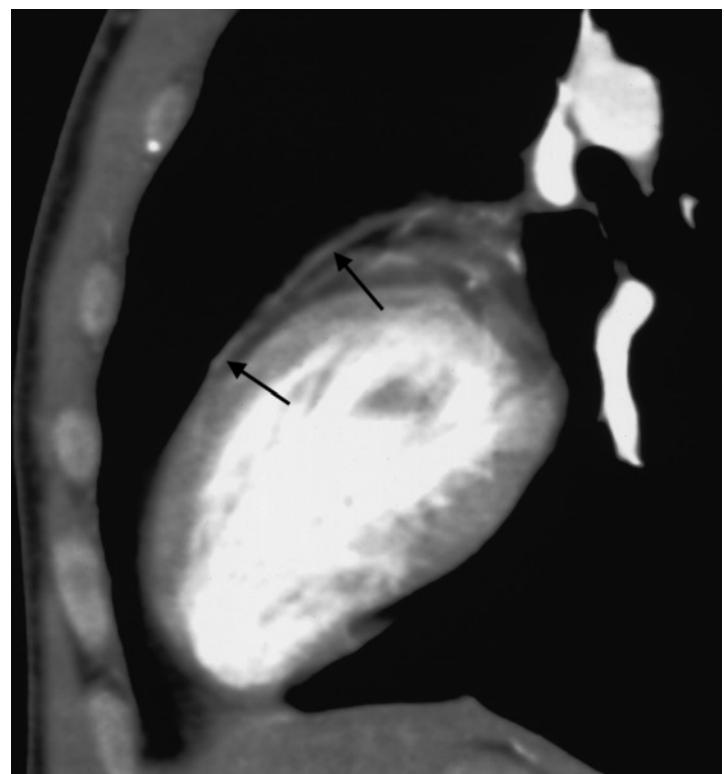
Visualization of the course of the anterior interventricular artery on a sagittal reconstructed plane in chest CT. The long course of the artery (black arrows) is visualized on the sagittal reconstruction.
